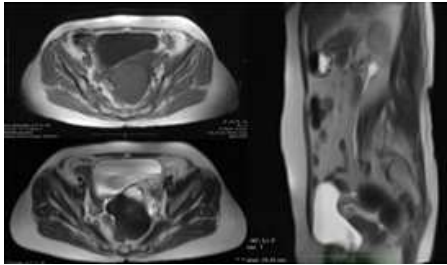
and 2c (counter clock-wise): Non-contrast T1 axial (2a), T2 axial (2b) and T2 coronal (2c) images of pelvis show T1 isointense and T2 hypointense homogeneous solid lesion in the pouch of Douglas. The lesion showed no diffusion restriction on DWI images (not shown here).
